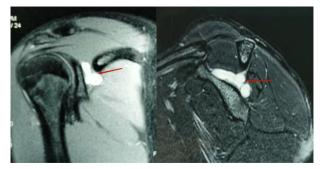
MRI shows a huge cyst at the right shoulder glenoid notch
